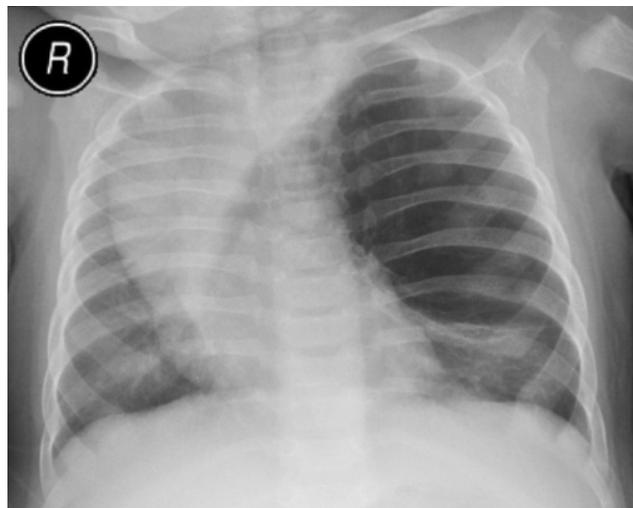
Chest x-ray of a 3-month-old male with congenital lobar emphysema, demonstrating hyperinflation of the left upper lobe with mediastinal shift towards the right (image from Radiopaedia, case contributed by Dr. Fakhry Mahmoud Ebouda).
